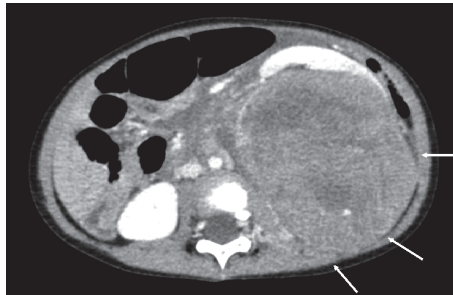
Axial view of the contrast-enhanced computed tomography before chemotherapy Imaging reveals a large heterogeneous pathological mass in the left kidney (white arrows).
